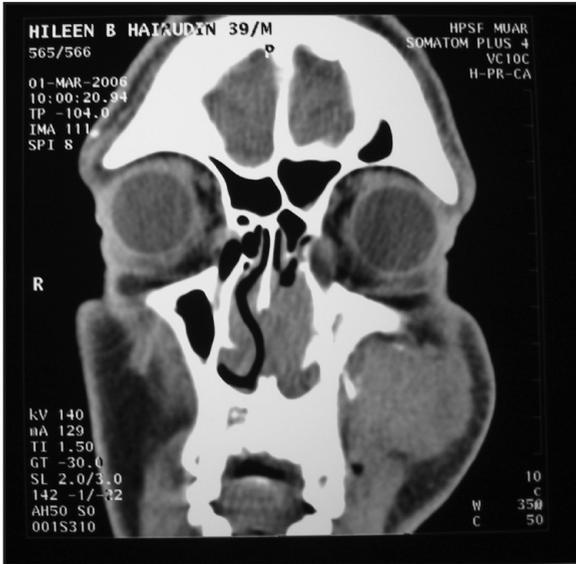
CT scan coronal view showing the tumour involving the left maxillary sinus
